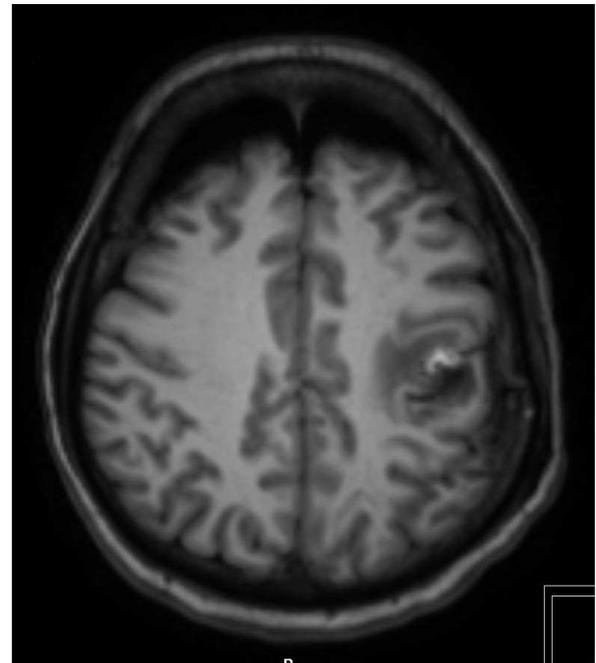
Post-operative MRI scan
